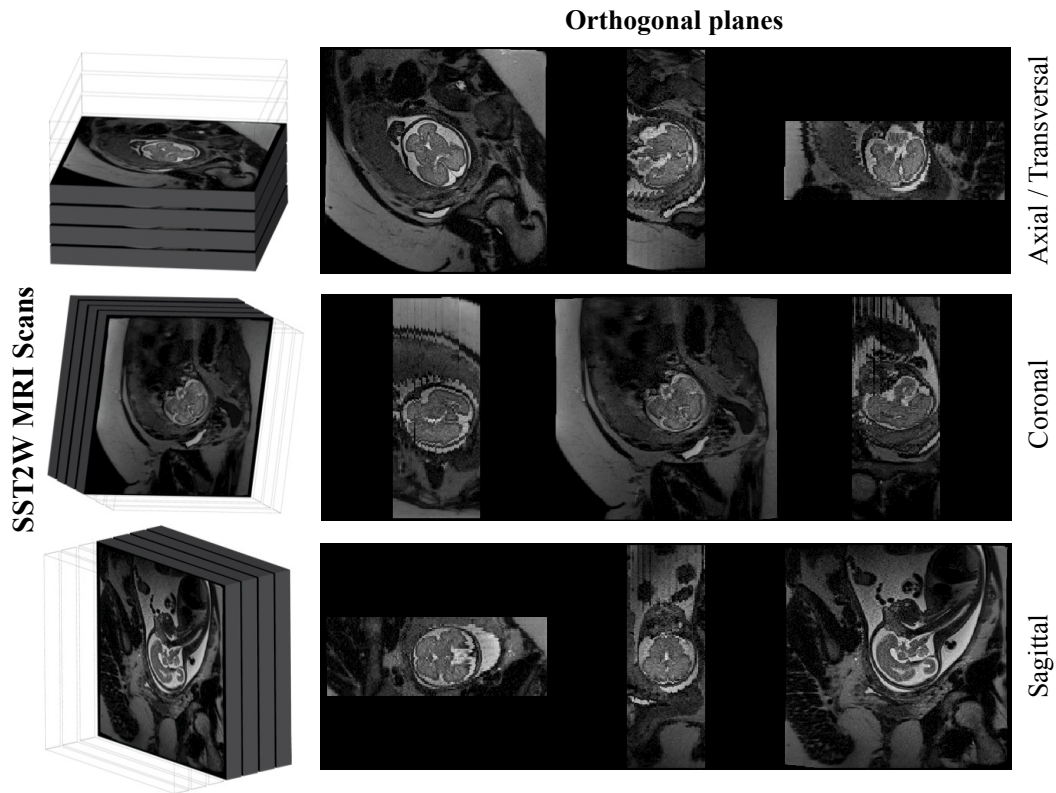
Clinical orthogonally-planned MRI scans of fetus of 27 weeks of gestational age. Acquisitions were done with a Siemens Skyra 3*Tesla*, HASTE (SST2W) sequence (TR: 1600ms, TE: 116ms, slice thickness: 2.0mm, in-plane resolutions: $1.0 \times 1.0mm^2$).
